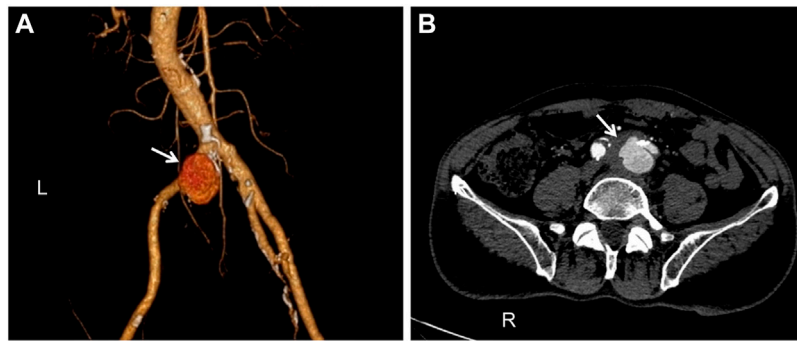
Computed tomography angiography (CTA): (A). The pseudoaneurysm has a maximum diameter of 33 mm and is placed near the commencement of the left common iliac artery (white arrow). (B). A breach is visible in the arterial wall, and there is an overflow of contrast agents (white arrow).
